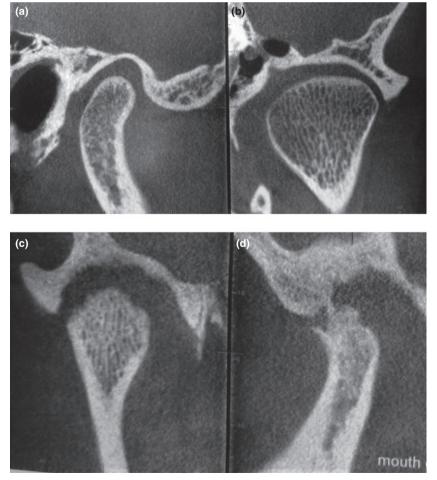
(a) Cone-beam CT scans showing a normal mandibular condyle in the sagittal and (b) coronal planes while (c) and (d) show a severely degenerate mandibular condyle on the right. Surgery is a viable option for the management of TMJ advanced degenerative joint disease like the case depicted in (c) and (d)
